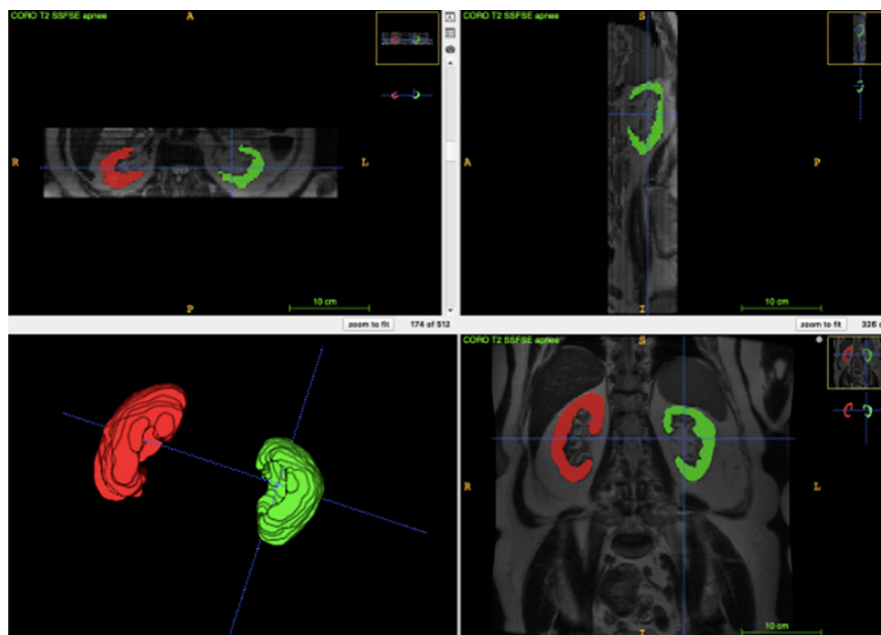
MRI manual renal segmentation on ITK SNAP 3.8.0
